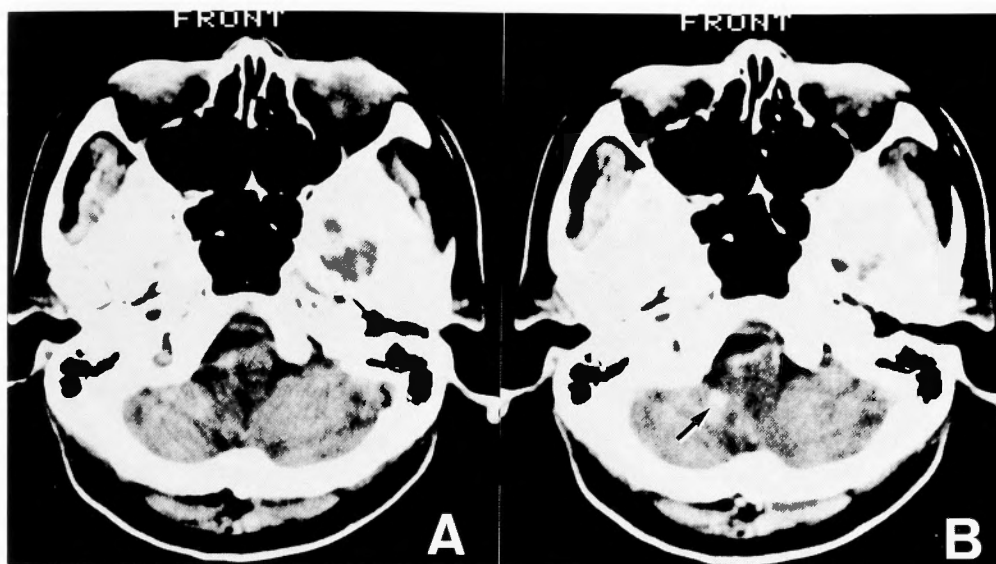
CT scans with (B) and without (A) contrast enhancement show an aneurysm on the inferior ventromedial surface of the right cerebellum (arrow).
